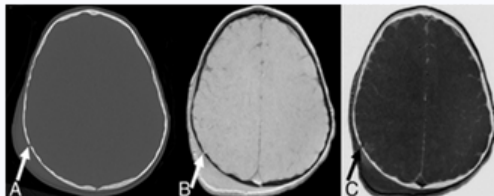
CT scan (A) MR Image with Black bone sequence (B) Inverted BB image (C)
